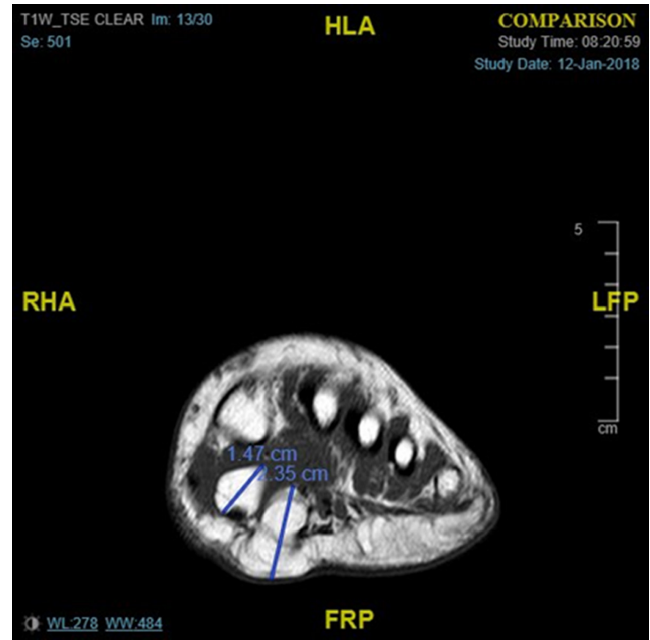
Pre-operative MRI images
